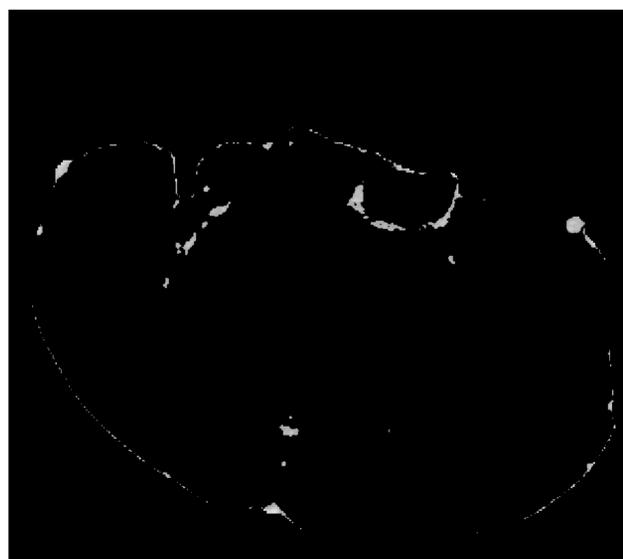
Contoured brain image only showing pixels with a CT number in the range of the contrast injected
